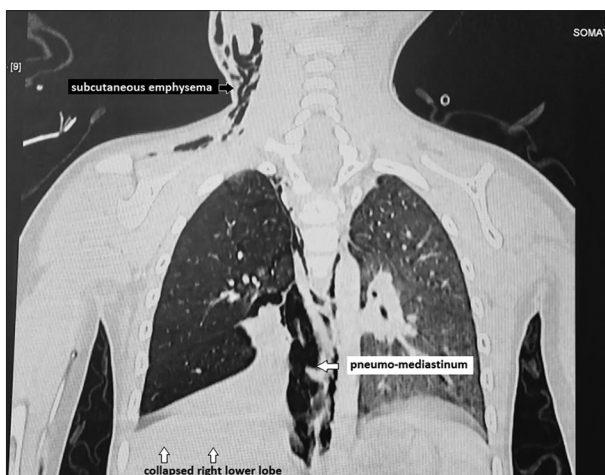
CT scan image showed pneumomediastinum, pneumopericardium, subcutaneous emphysema, pneumothorax with collapsed right lower and a hyper-inflated right upper lobe
